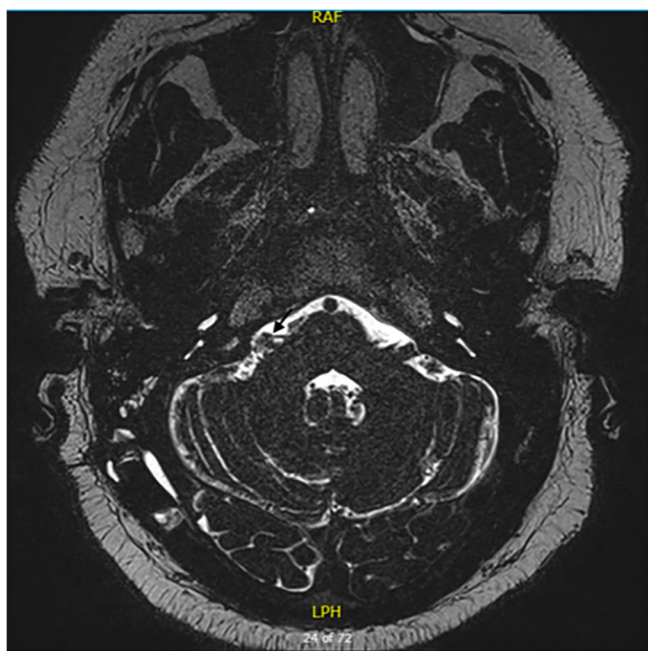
Axial T2 weighted magnetic resonance image demonstrating separation of the vessel loop from the root entry zone of the facial nerve (arrow).
